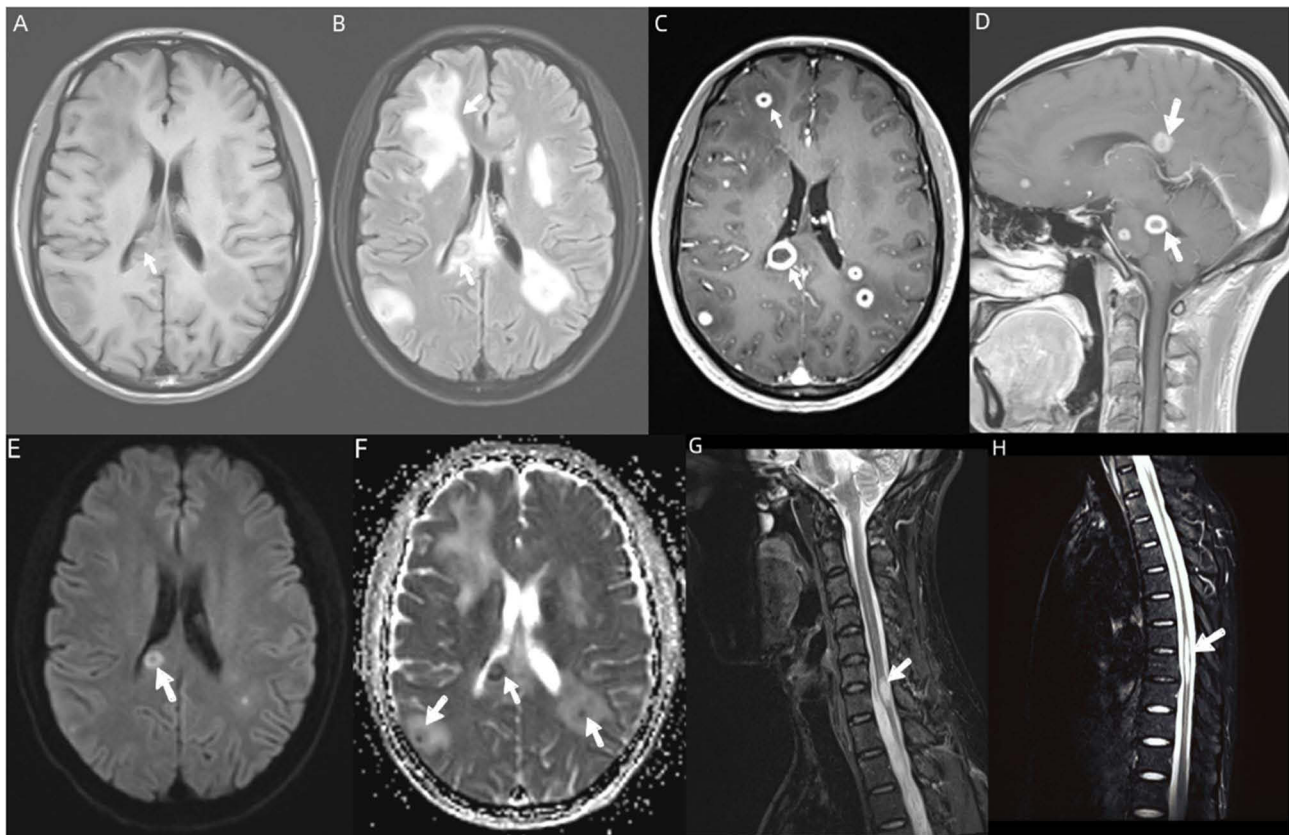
(A and B) Bilateral cerebral hemispheres, cerebellum, and brainstem with multiple patchy low-signal lesions on T1WI, high signal on T2-FLAIR, and different degrees of edema around the lesions with marked edema (white arrows); (C and D) Post-contrast Magnetic resonance imaging showed nodular and ring-like enhancement, and no enhancement in the center of the lesion (white arrows); (E and F) DWI shows ring and point high signal shadows with reduced ADC values (white arrows). (G and H) MRI showed localized dilatation of the central canal of the cervicothoracic and thoracolumbar spinal cord, with abnormal signal lesions in the spinal cord (white arrows).
